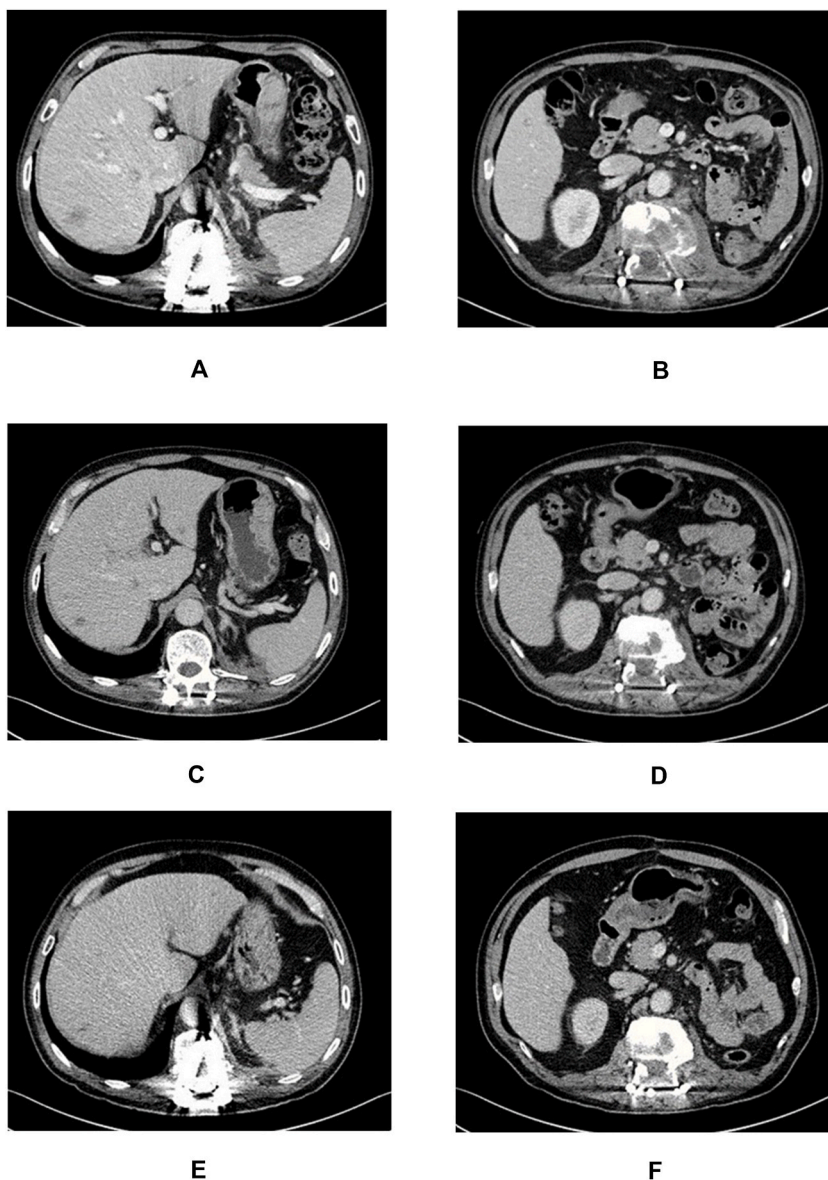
The CT scan of case 1. A&B. The left renal pelvic carcinoma with multiple metastases in liver and lumbar spine. C&D. Partial response after the patient received RNU with subsequent 4 cycles of camrelizumab. E&F. The stable lesion after 8 cycles of camrelizumab.
